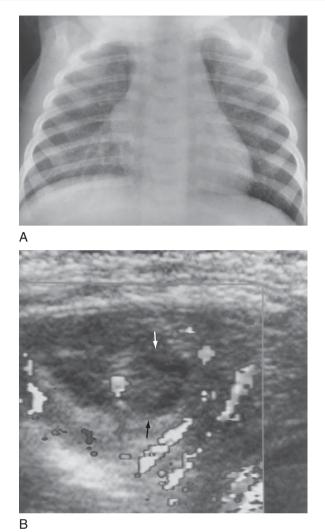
Occult lung abscess. Pneumonia in the right middle lobe in an 18-month-old boy did not respond to antibiotic therapy as expected. A, Chest radiograph demonstrates a straightforward pleuropneumonia in the right middle lobe without volume expansion or an air-containing cavity. B, Sonography demonstrates a mostly avascular hypoechoic lesion within the consolidation (arrows). Black-and-white rendering of a color Doppler examination of the infiltrate demonstrates pulmonary vessels supplying the lung around the abscess and a still-vascular nodule within the abscess.
